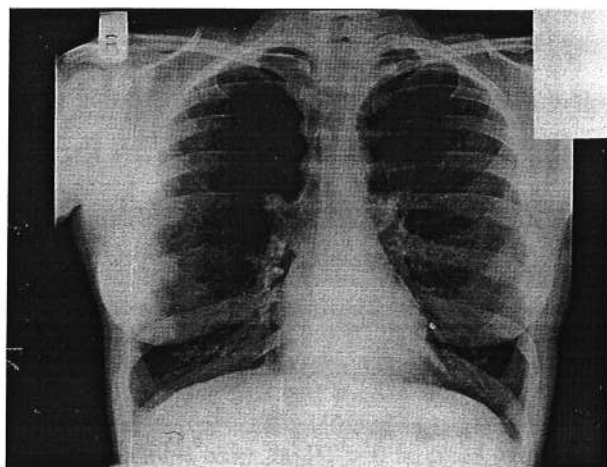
Patient's chest radiograph showing the metal butterfly *in situ*.
